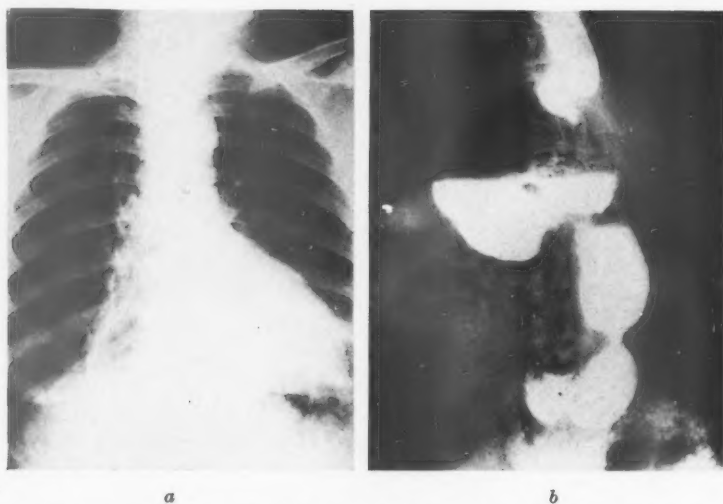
Rolling hernia. (a) Plain X-ray of the chest, showing a cystic area to the right of the heart. (b) The same patient on barium examination
